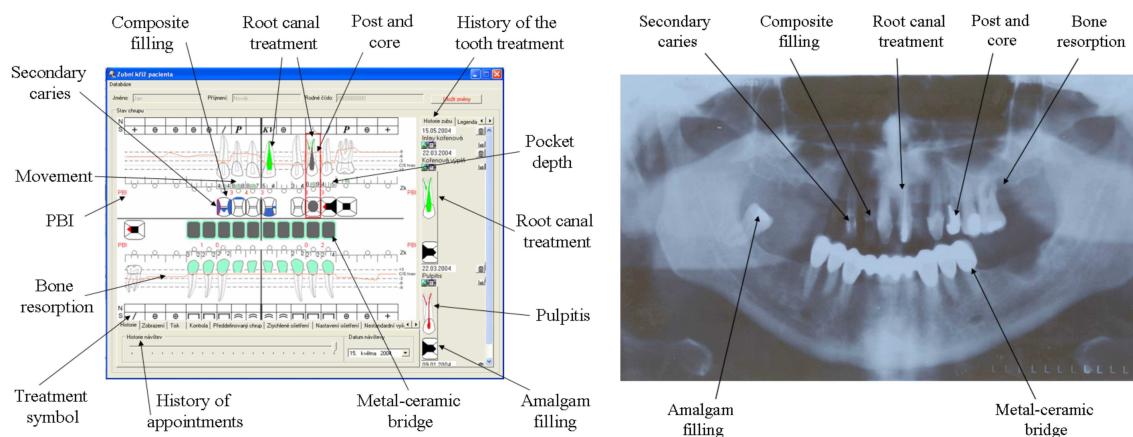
DentCross Component and its comparison to orthopantomogram.
